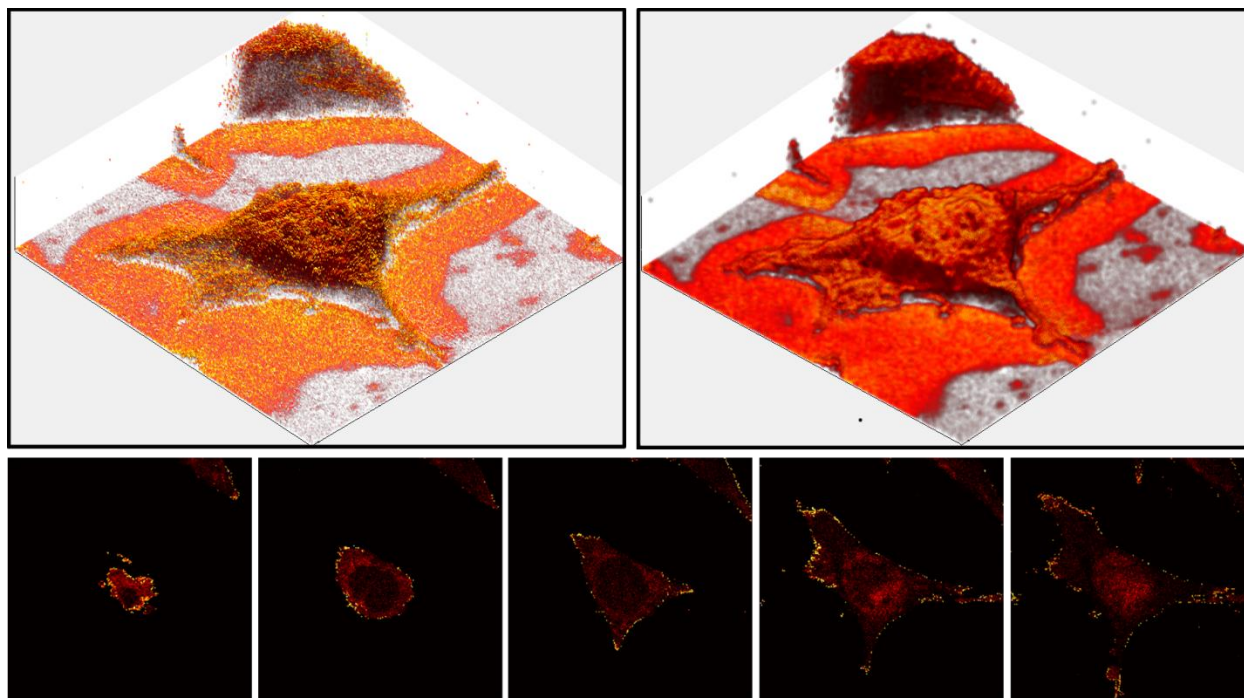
Visualization options provided by the ZcorrectorGUI. The data set consists of 56 images. Each image contained 256x256 pixels and was $86 \times 86 \mu\text{m}^2$ in size. (A) An image of the $m/z 58^+$ signals from a corrected data set of a single NIH/3T3 fibroblast. (B) The same data from A, after smoothing. (C-G) A series of corrected XY images of the $m/z 58^+$ peak intensities. With the corrected data, one can move through the cell vertically in a similar fashion as a CT scan moves through tissue. C is at the top of the cell, while G is near the bottom of the cell.
